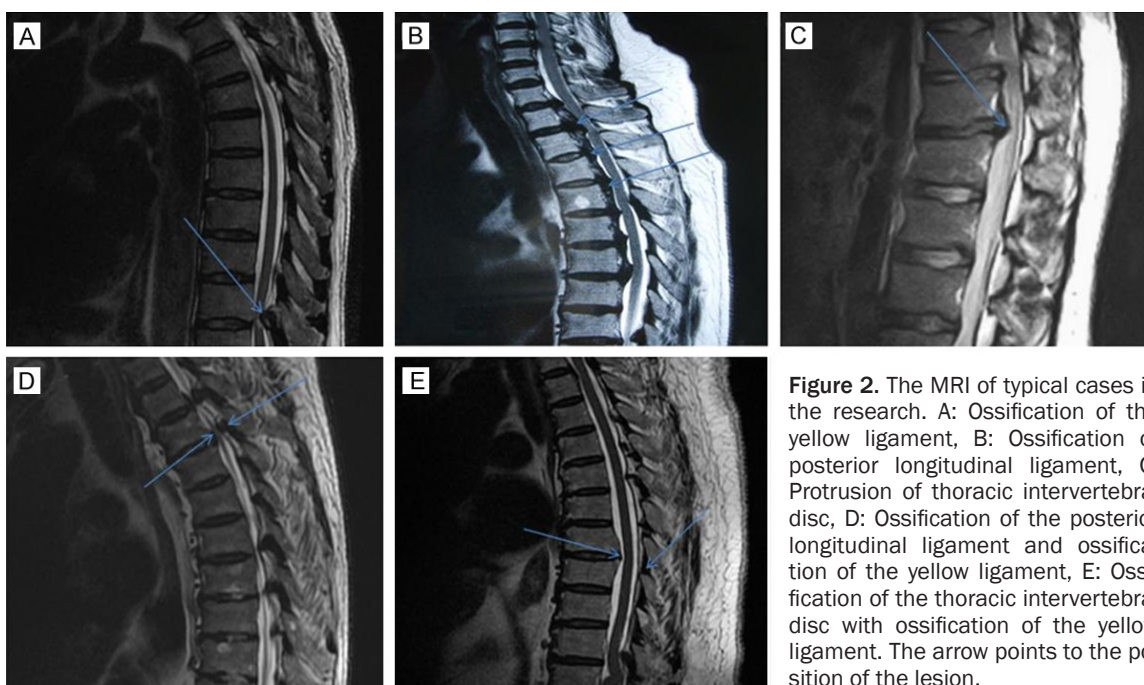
The MRI of typical cases in the research. A: Ossification of the yellow ligament, B: Ossification of posterior longitudinal ligament, C: Protrusion of thoracic intervertebral disc, D: Ossification of the posterior longitudinal ligament and ossification of the yellow ligament, E: Ossification of the thoracic intervertebral disc with ossification of the yellow ligament. The arrow points to the position of the lesion.
